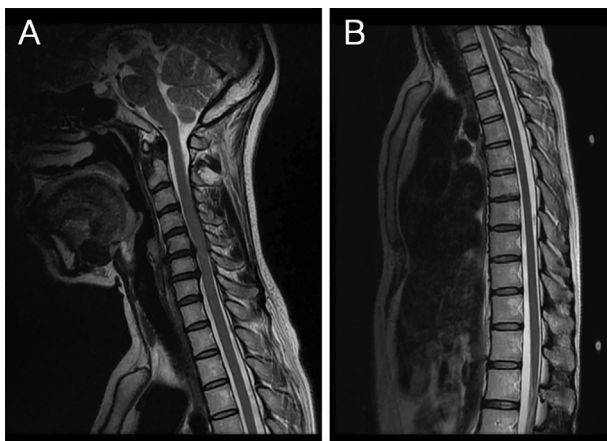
Magnetic resonance imaging (MRI) of the cervical and thoracic spinal cord. Mild cervical spondylosis of C4/5 and C5/6 was noted (A), but no abnormality was observed in the thoracic region (B).
